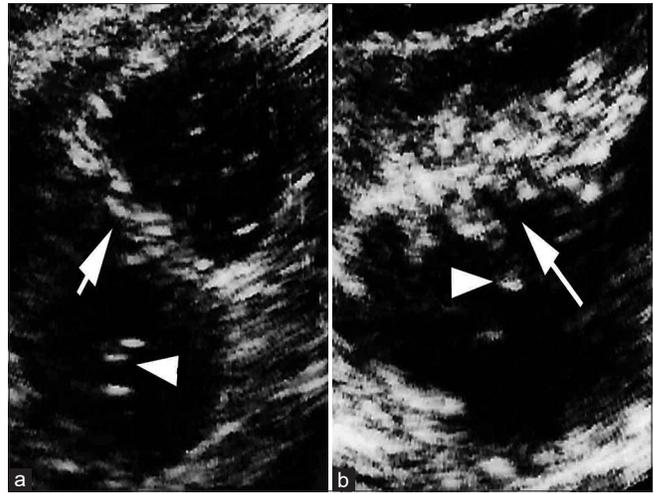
(a and b) Sample sonogram of the colon in acute giardiasis in the ascending (a) and descending (b)
